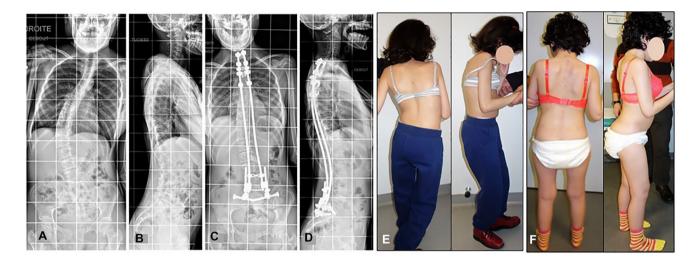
a–d Radiographs and photographs of a 12-year-old girl with cerebral palsy, pelvic obliquity $< 10^{\circ}$ but severe trunk imbalance. a pre-operative radiographs. b postoperative radiographs. c preoperative photograph. d after 5-years follow-up
